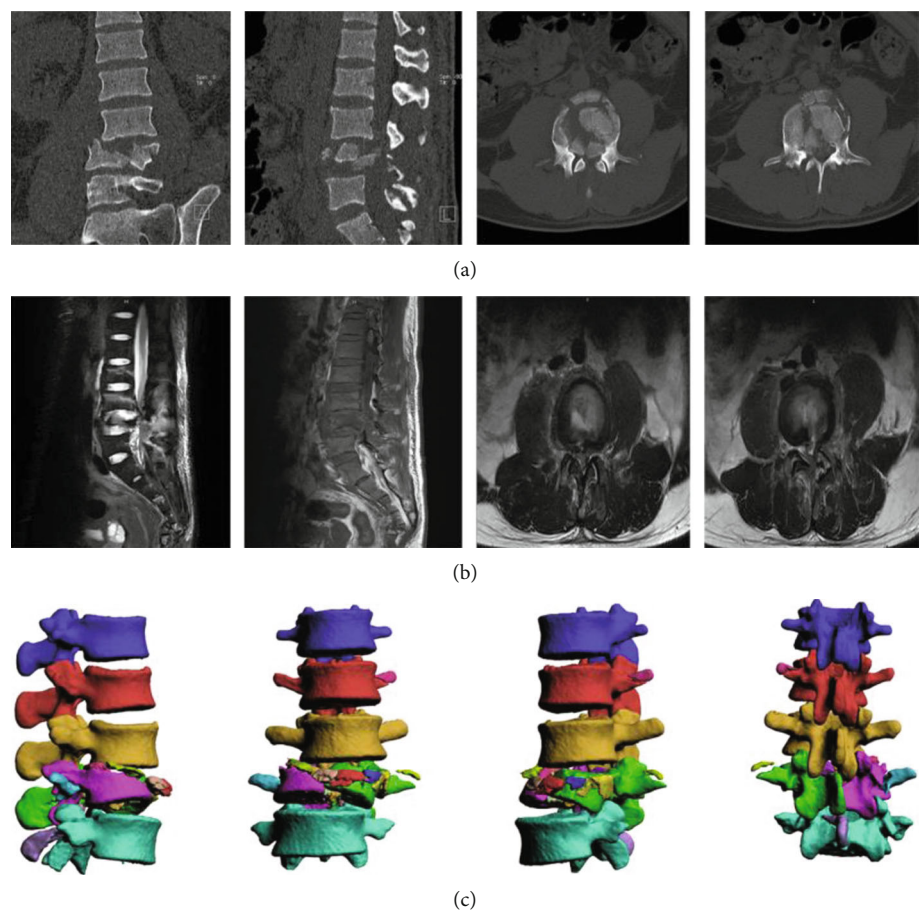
A typical UPA case. A 65-year-old man with LF (L2-L4). (a) CT of lumbar presurgery. (b) MRI images of the injured lumbar in the sagittal and the coronal plane. (c) Three dimensional CT images of lumbar.
